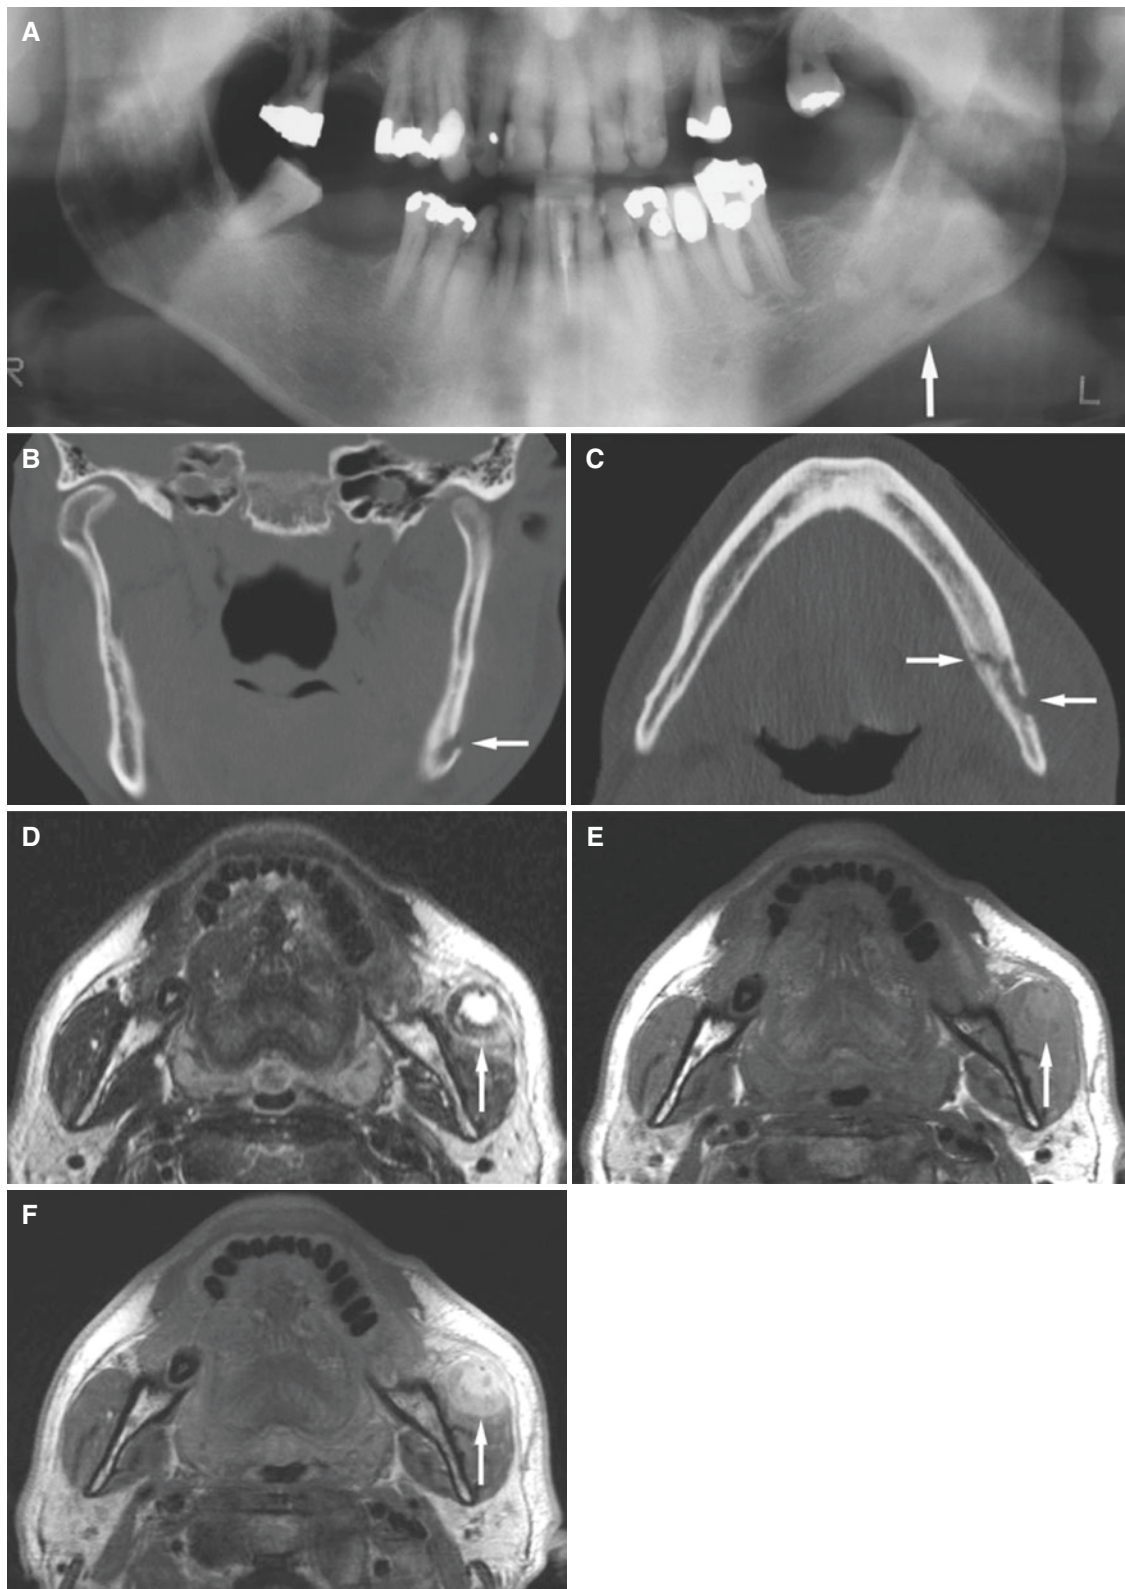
Osteomyelitis with spread to masseter muscle; 55-year-old male with variable swelling in parotid and cheek area after tooth extraction many months previously, no pain. (A) Panoramic view shows sclerotic mandible with suggestion of small destruction (arrow). (B) Coronal CT image shows buccal cortical destruction (arrow). (C) Axial CT image shows buccolingual destruction (arrow) and slight periosteal
